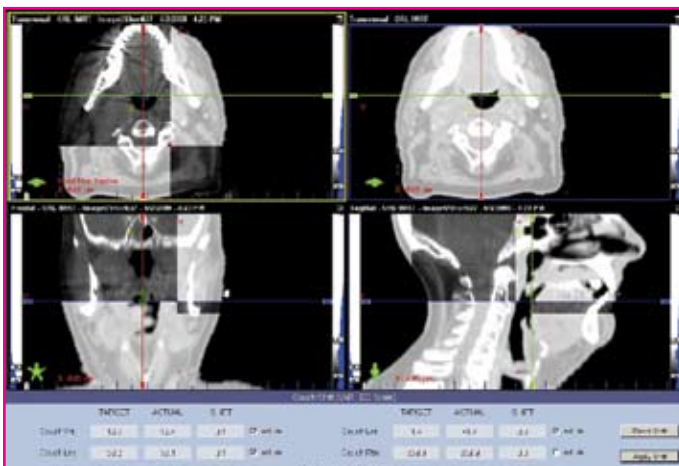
The possibility to acquire rapid daily in-room CT imaging (CBCT) allows adaptive dose guided radiotherapy.
